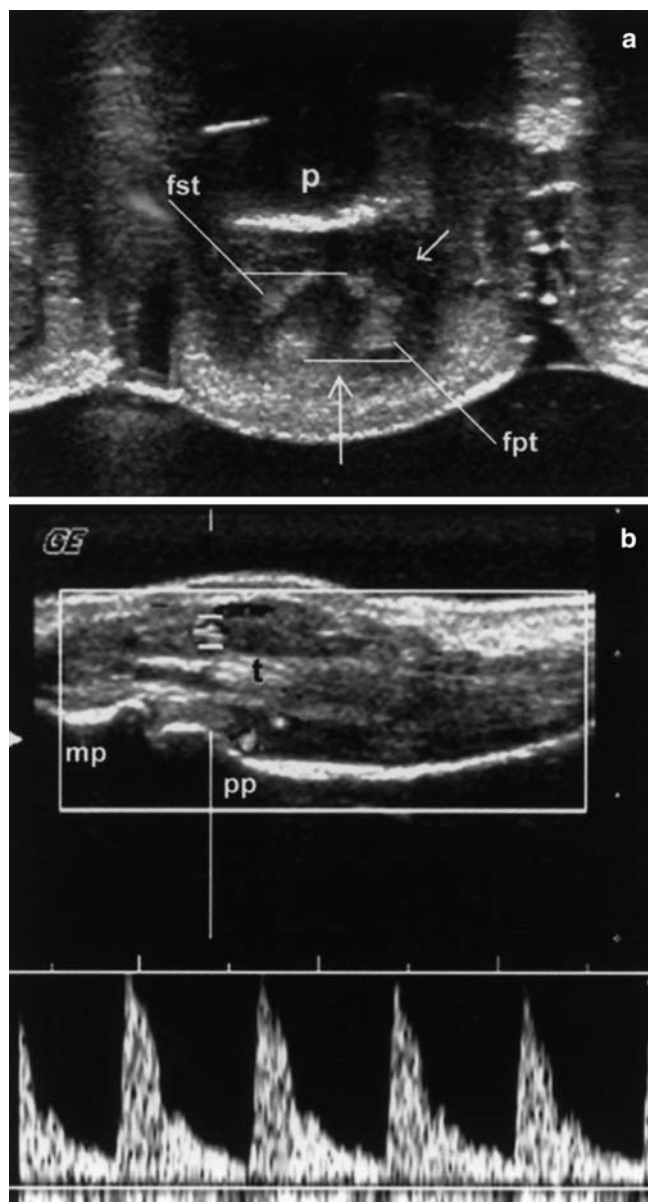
Rheumatoid arthritis with hypertrophic tenosynovitis. a Axial ultrasound image. b Sagittal duplex Doppler image. Flexor tendon surrounded by hypertrophic synovial seen as a soft tissue (arrow), and fluid (small arrow). The hypertrophic synovium presents evident arterial Doppler flow. mp middle phalanx; p phalanx; pp proximal phalanx; t flexor tendon
